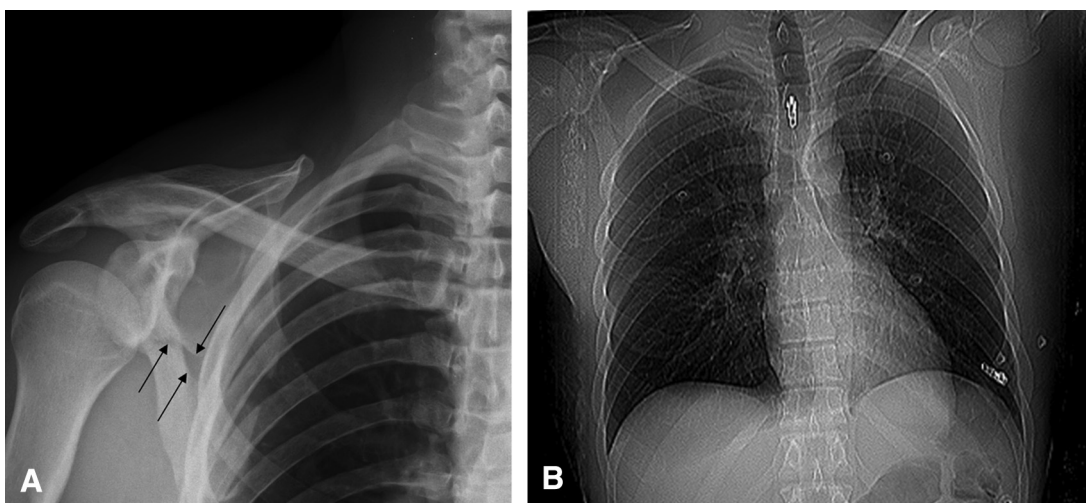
Right shoulder x-ray study (A) shows a nondisplaced scapular fracture (arrows). Supine chest x-ray study (B) shows no signs of rib fractures, pulmonary contusions, or pneumothorax.
